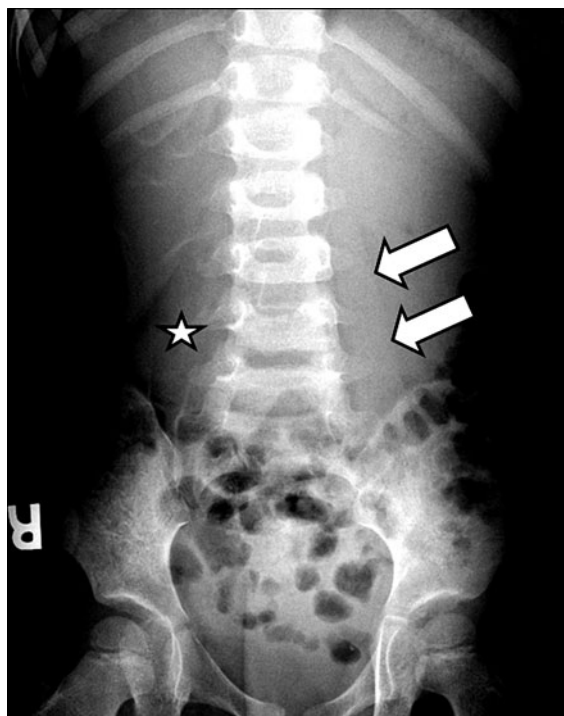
Three-year-old girl with appendicitis. Upright abdominal radiograph demonstrates loss of the right psoas muscle contour (*star*). The normal appearing left psoas margin (*arrows*) is seen
